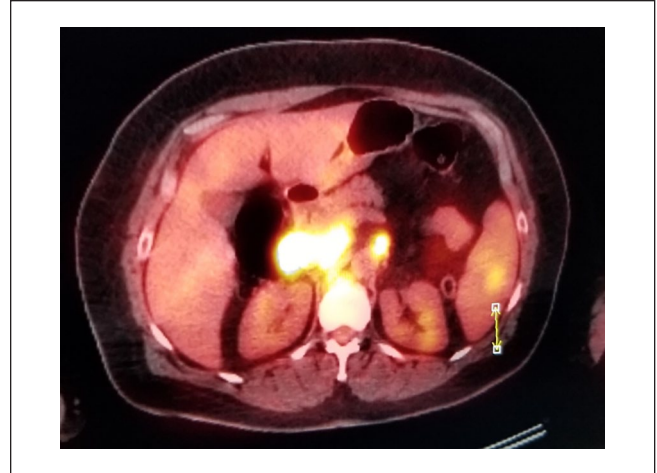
PET-CT demonstrating focal splenic lesion.
